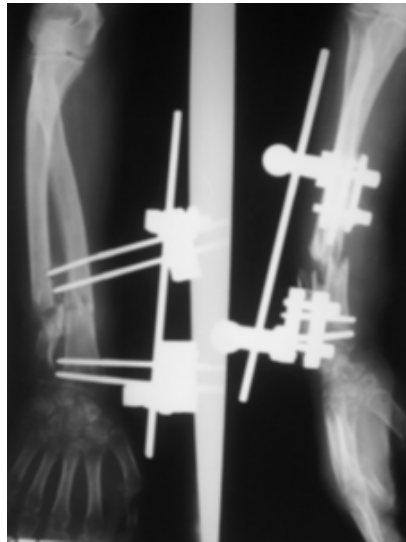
X-ray of a fracture of both forearm bones complicated by pseudarthrosis
